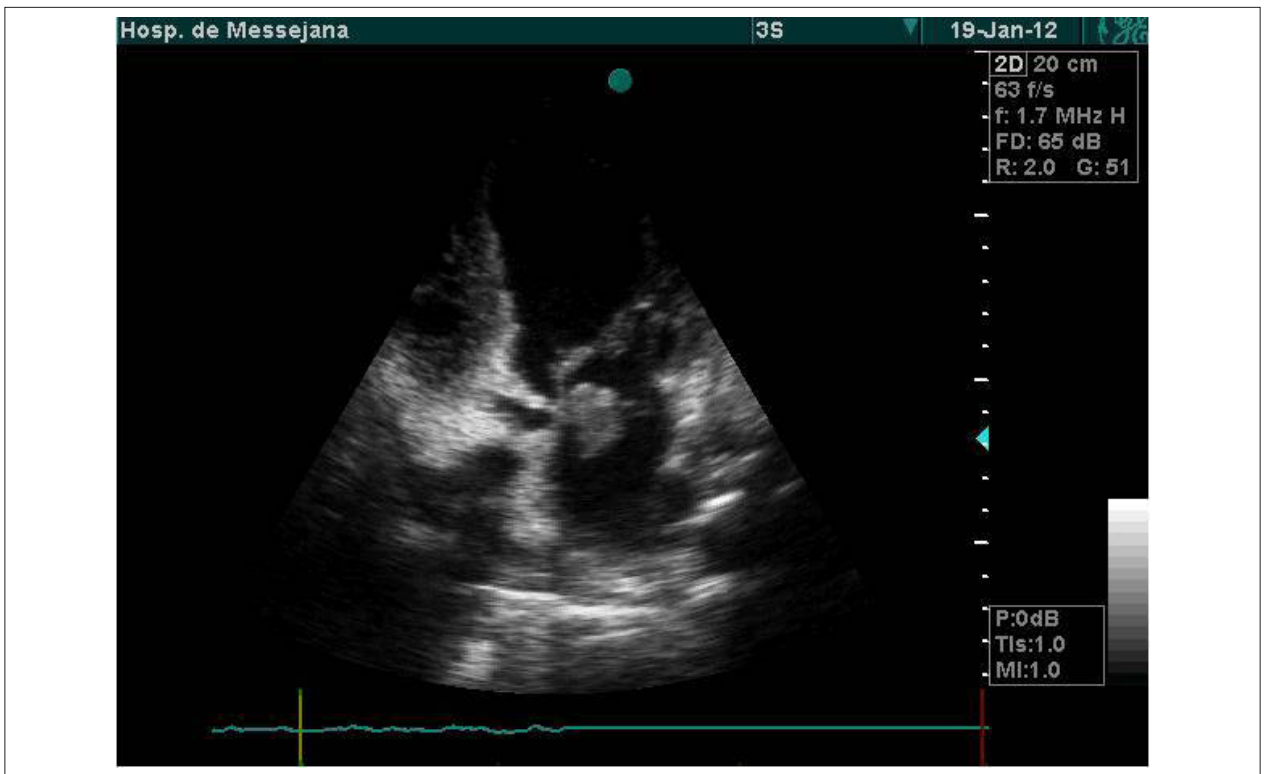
Apical five-chamber view with mobile image measuring about 6 x 7 mm near the left atrial septal wall suggesting vegetation.
